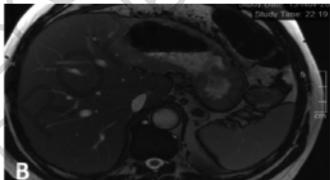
A) Upper abdominal CT image of the patient. The arrow indicates that hydatid cyst involving segment 2 and 3 of the liver resulted in cystogastric fistula. Oral contrast matter filling to the cyst cavity can be seen. Upper abdominal MRI of the patient; B) The MRI revealed similar findings with CT in addition to absence of cystobiliary fistula.
